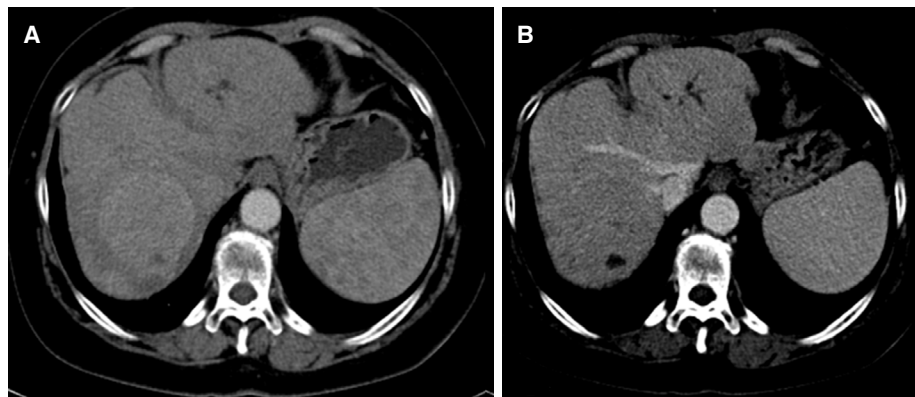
Contrast enhanced computed tomography revealing a 9.2 cm × 8.9 cm × 11.0 cm mass in the right lobe of the liver. (A) Arterial phase shows diffuse enhancement; (B) venous phase shows washout
